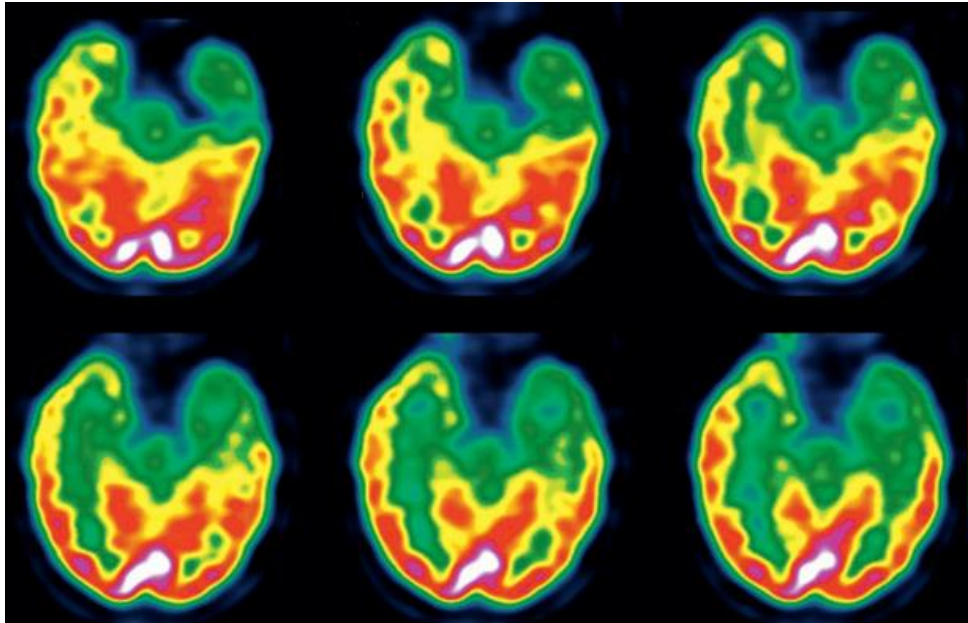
Interictal FDG-PET study in a patient with temporal lobe epilepsy. Reproduced with permission of Elsevier from (Kumar et al., 2012).
